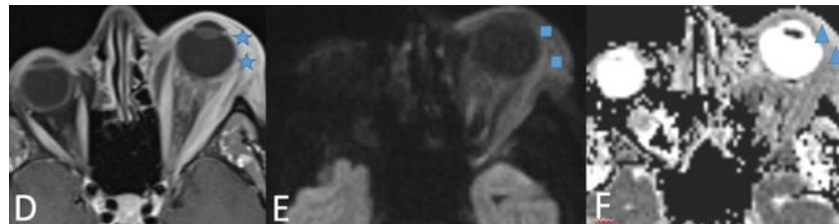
Gadolinium-enhanced 3D T1 VIBE (D, blue stars) shows contrast enhancement of the left lateral rectus muscle and upper eyelid. DWI at $b = 1000 \text{ s/mm}^2$ (E) and ADC map (F, arrowheads) demonstrate no diffusion restriction with elevated ADC values, distinguishing acute inflammatory disease from lymphoproliferative or neoplastic infiltration.
